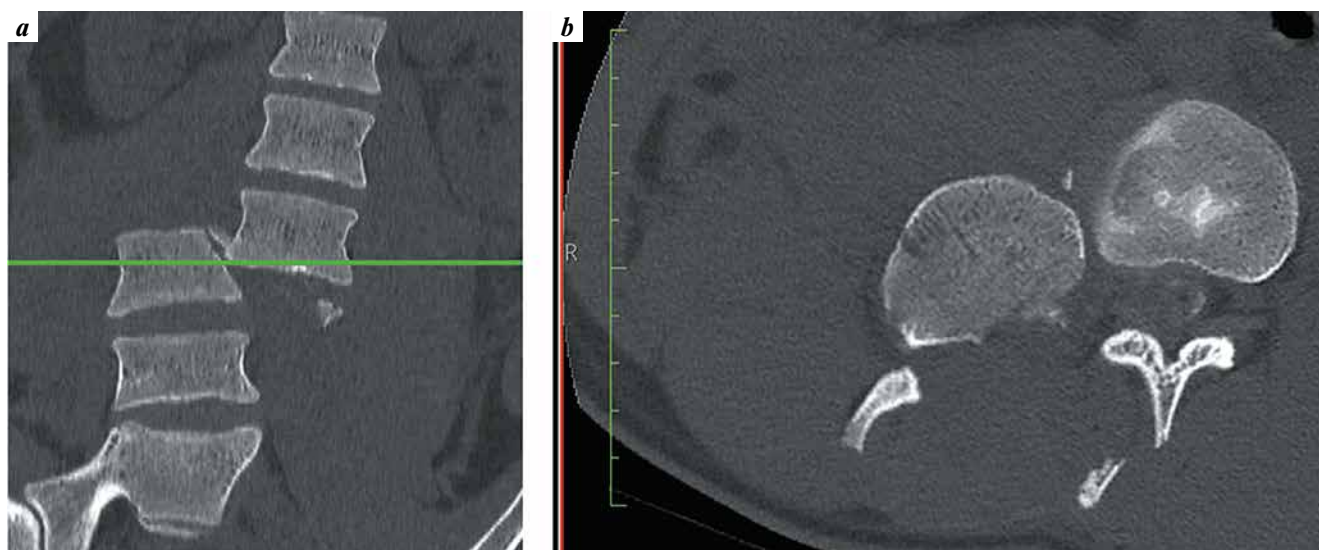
Lumbar computed tomography showing L_3 – L_4 dislocation (a). Lumbar computed tomography showing the L_3 – L_4 dislocation (b)
